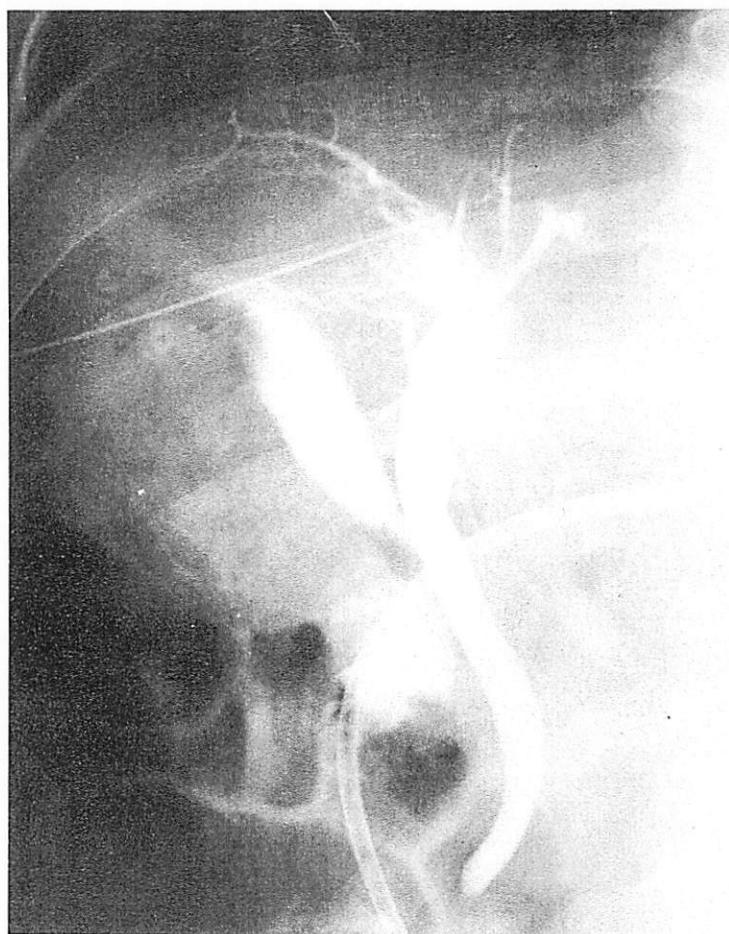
In this patient with cirrhosis (Case 7), the right lower half of the liver was missing or cold on the scintigram, and hepatoma was suspected. The cholangiogram revealed an unusually small, shrunk right lobe, with a displaced gallbladder to point cephalad. The bundle of streaks running toward the porta hepatitis represents lymphatic channels.
